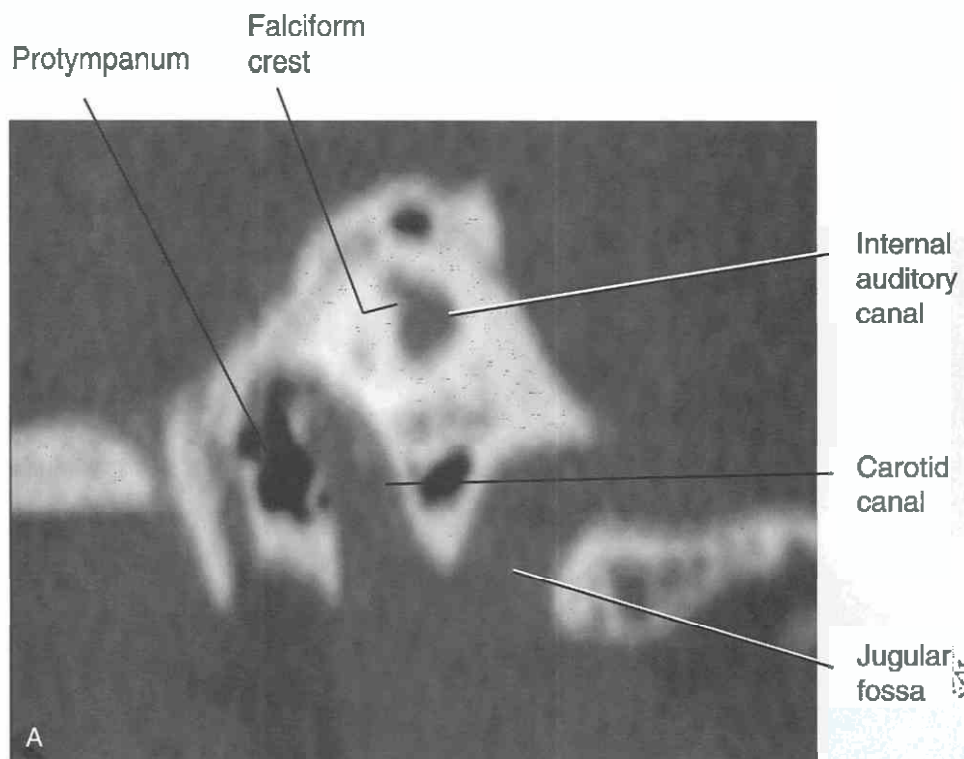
Sagittal views, normal anatomy. *A*, This sagittal CT reconstruction is the most medial section and is centered at the protympanum, carotid canal, internal auditory canal, and jugular fossa. Note the close association of the protympanum and the carotid canal. The internal auditory canal demonstrates a small anterior pointed indentation resulting from the falciform crest that separates the facial and cochlear nerves. *B* and *C*, Sagittal MR sections.
